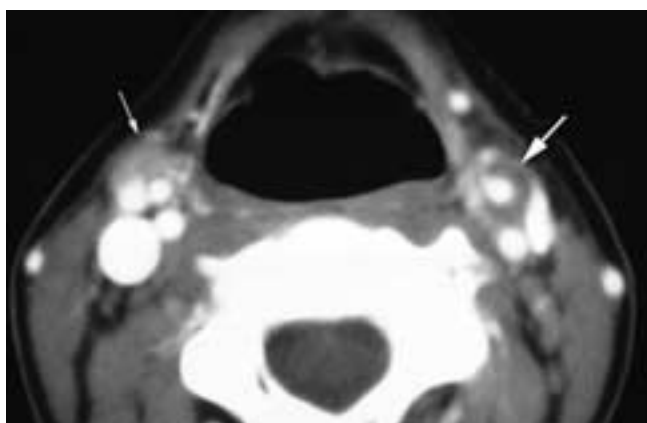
Axial contrast-enhanced CT scan on a patient who has had RT shows a zone of nonenhancing soft tissue (*large arrow*) around the left carotid artery. This was radiation-related arteritis. A level III node is present in the right neck (*small arrow*).
